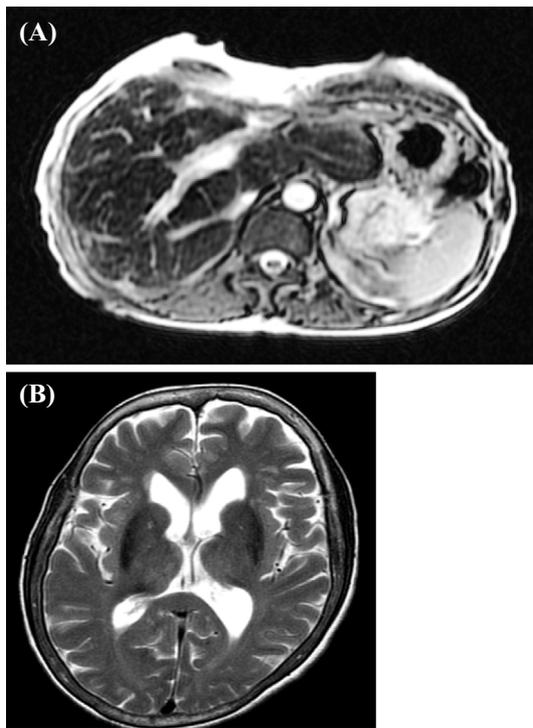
T2-weighted magnetic resonance images of the liver (A) and the basal ganglia in the brain (B). Abnormal hypointensity was observed on T2-weighted magnetic resonance imaging of the liver and brain.
